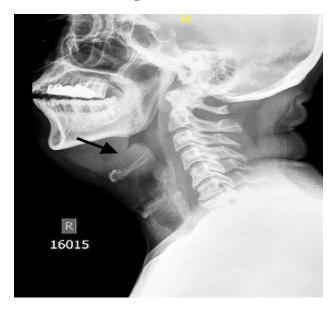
6: Plain X-ray soft tissue neck showing thickened epiglottis with obliteration of vallecula in a patient with tuberculosis of larynx mimicking acute epiglottitis.
